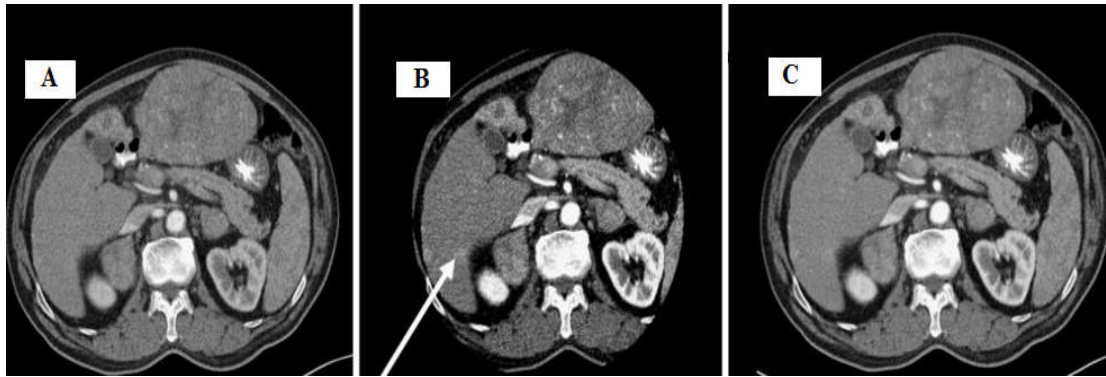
Contrast-enhanced CT images for a 64-year-old man with hepatocellular carcinoma (a small lesion): A) 140-kVp image, B) 80-kVp image, and C) averaged image generated with dual-energy CT. The 80-kVp image shows a hyperattenuated lesion (arrow), which is not identified on corresponding 140 kVp and dual-energy averaged images (Altenbernd et al., 2011)
